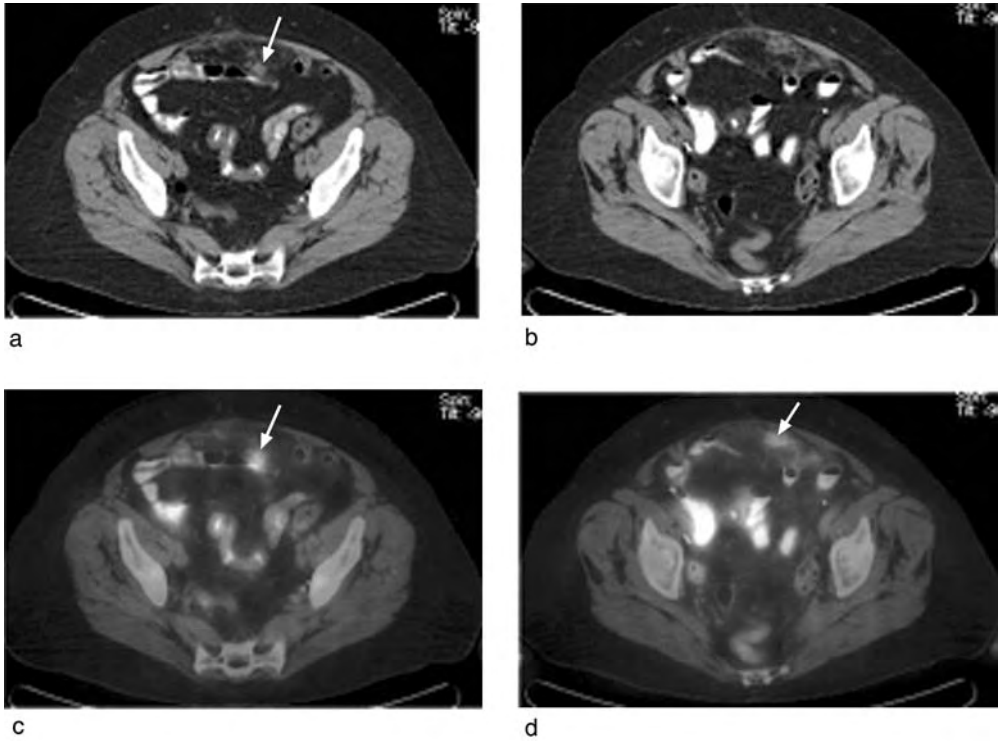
(a+b) Patient with omental tumour recurrence on CT (arrowed). (c+d) These multiple small omental masses demonstrate increased FDG uptake (arrowed). (For a colour version of this figure please refer to colour plate section.)
